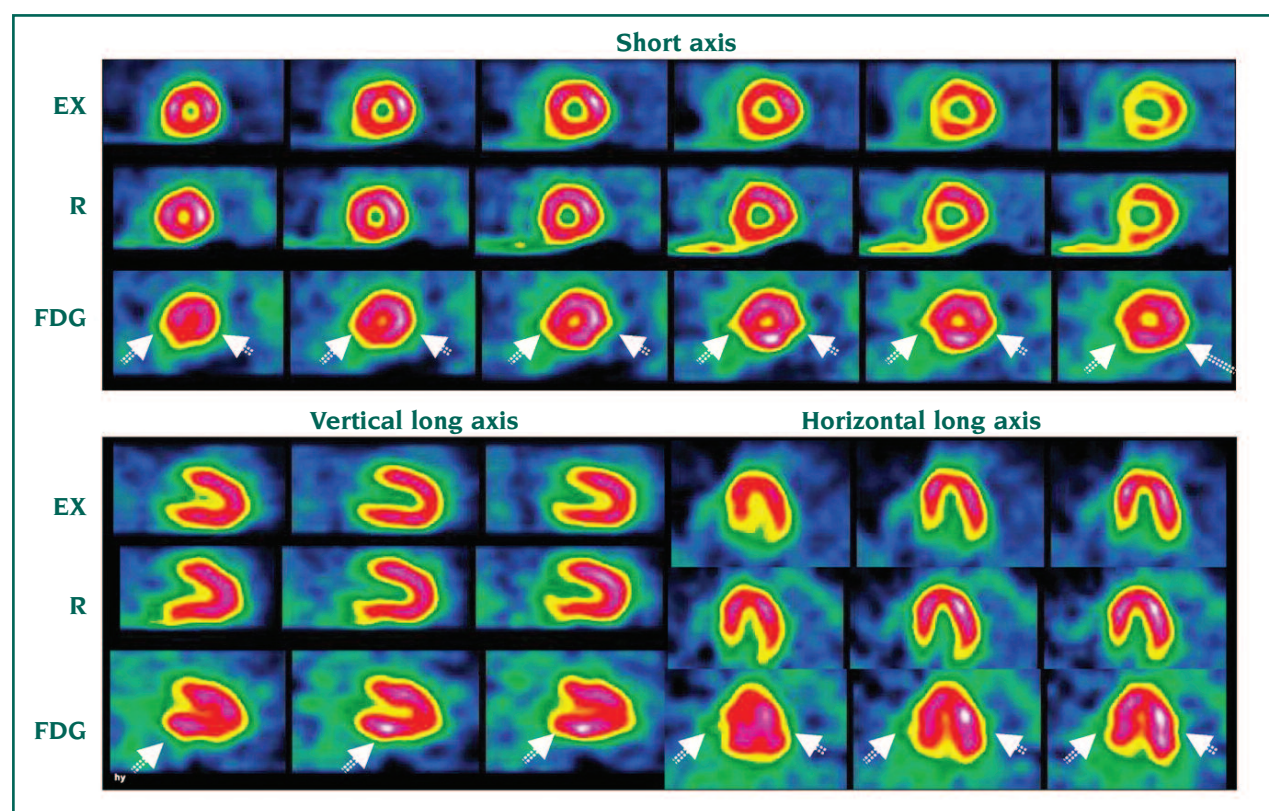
Exercise (Ex) and rest (R) Tc-99m sestamibi and exercise F-18-FDG images in a patient with 3-vessel CAD.
